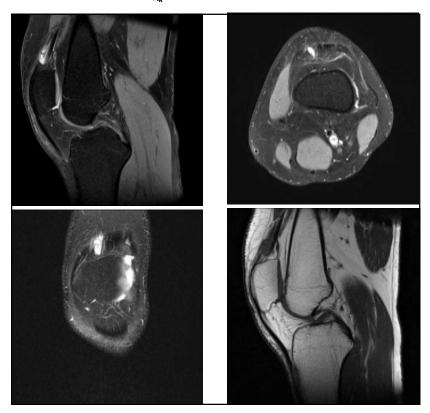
MRI Shows a Small 2.0 x 1.2 cm Cystic Lesion Within the Substance of Quadriceps Tendon on PDFS (Fig.1,2,3) and T1W (Fig.4) Images
